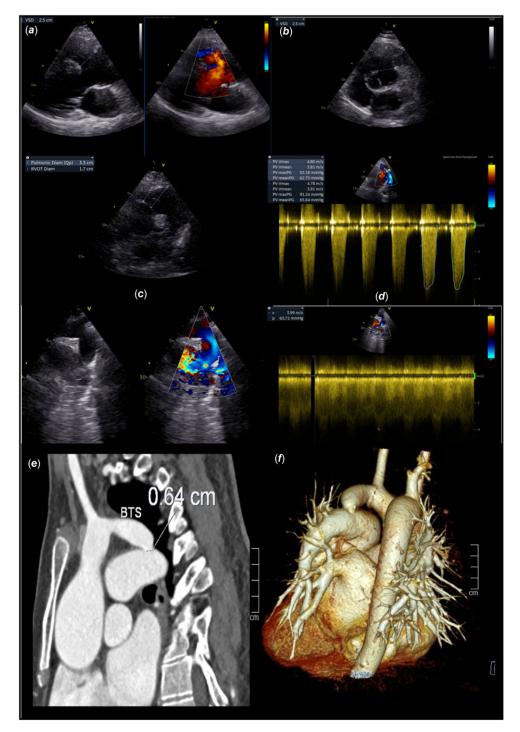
A-F: Echocardiography: Two-dimensional echocardiography with Doppler reveals uncorrected tetralogy of Fallot with an overriding aorta (A), a large perimembranous ventricular septal defect (A, B), right outflow tract stenosis (C, D) with high-pressure gradient of 92/62 mmHg, and marked right ventricular hypertrophy. In addition, it showed patent classic Blalock-Taussig-Thomas shunt between the left subclavian artery and the left pulmonary artery (E) with aliasing at the anastomosis with a pressure gradient of 63 mmHg (F). G: multi-slice computed tomography reconstruction showed the classic Blalock-Taussig-Thomas shunt. Noted a 6.4 mm anastomosis stenosis (white arrow), the dilated left pulmonary artery, and the right aortic arch.
